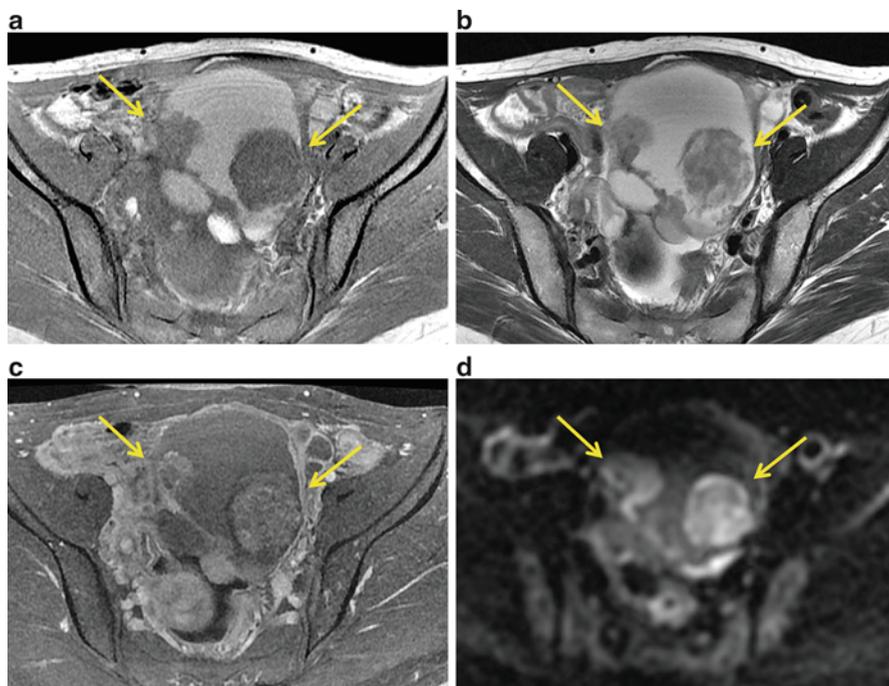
A 45-year-old woman with endometrioid adenocarcinoma associated with endometriotic cyst. Left endometriotic cyst shows hyperintensity on axial T1-weighted image (a) and absence of shading on T2-weighted image (b). The solid component (*arrows*) demonstrates contrast enhancement on contrast-enhanced T1-weighted image (c) and hyperintensity on diffusion-weighted image (d)
